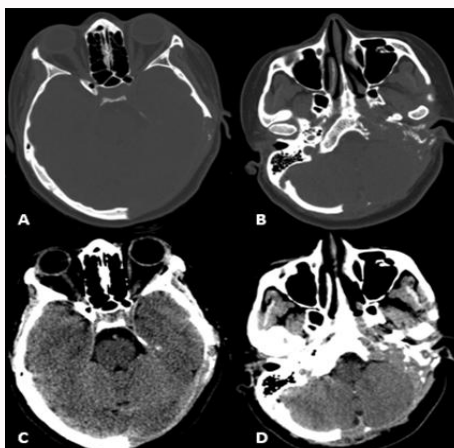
Axial head computed tomography (CT) bone window images (A,B) and soft tissue window images (C,D) revealing a left temporal osteolytic lesion, centered on the mastoid bone, affecting the tympanic bone and petrous apex, extending to the ipsilateral occipital bone and clivus. The osteolytic areas lack surrounding sclerosis and signs of periosteal reaction. Note the integrity of the adjacent brain parenchyma and the absence of soft tissue involvement.
